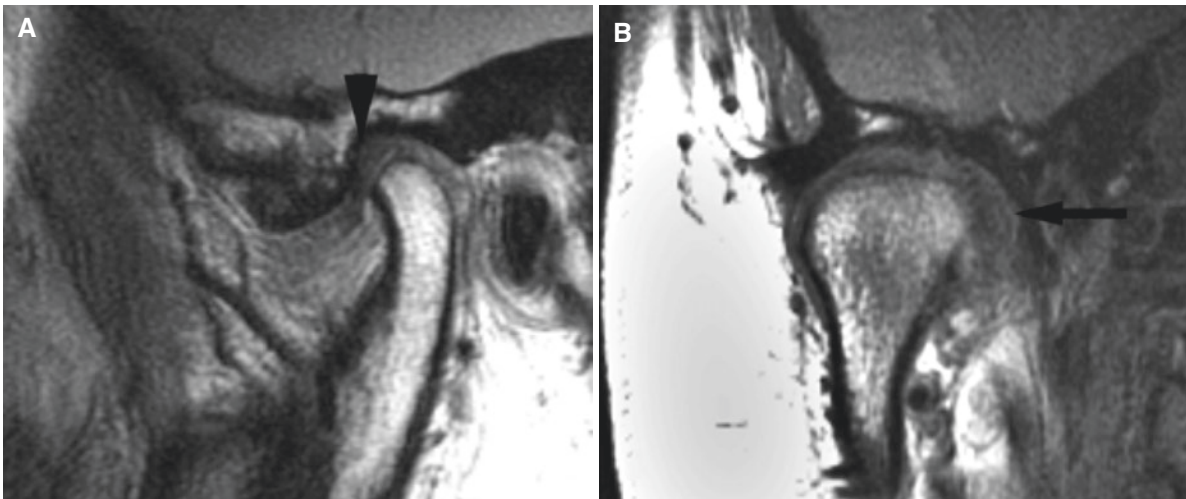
Medial disc displacement, normal bone. (A) Oblique sagittal MRI shows normal position of the disc (*arrowhead*). (B) Oblique coronal MRI shows medially displaced disc (*arrow*)
